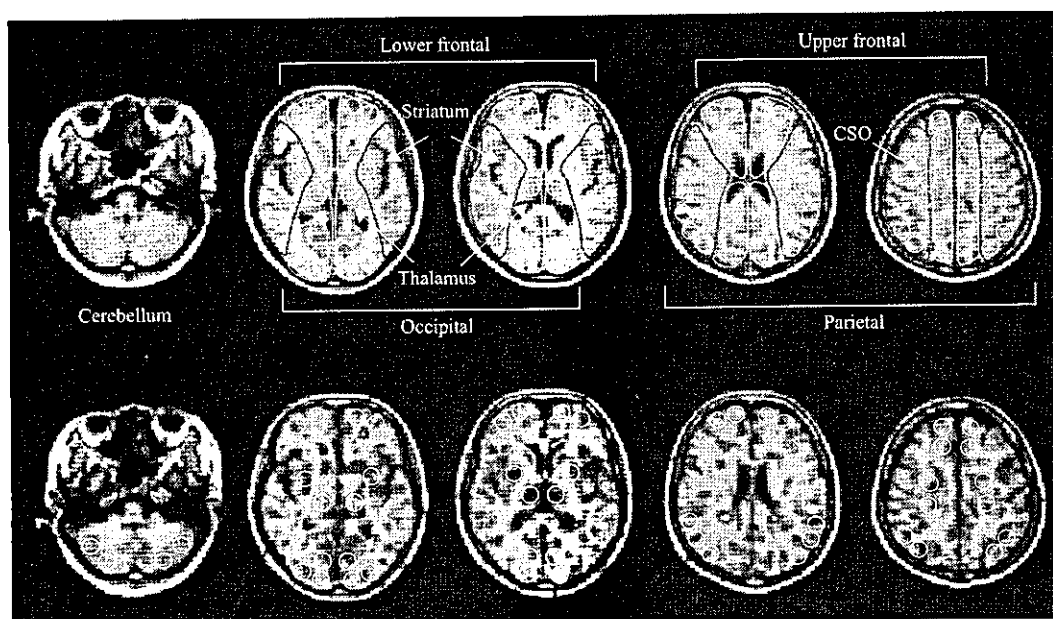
ROI setting. Multiple circular ROIs consisting of 96 pixels (1.58 cm²) were placed on the brain regions on the reformatted MR images (upper row) with the same pixel size as that of PET, which were automatically transferred onto the PET images (lower row). CSO, centrum semiovale.
